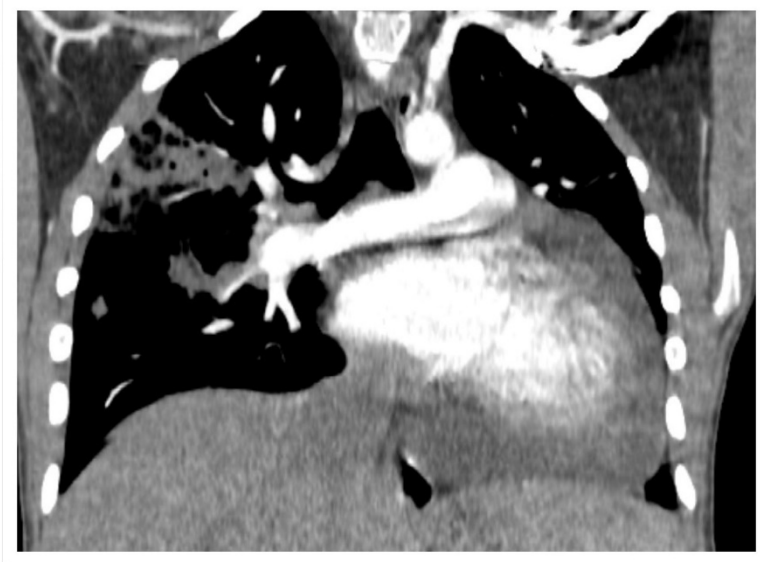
CT pulmonary angiogram demonstrating septic emboli, and pulmonary infarction
